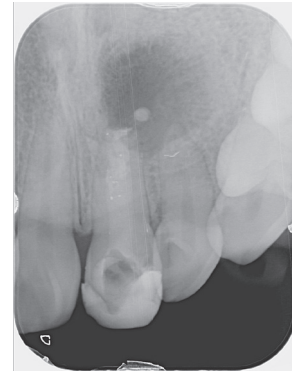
Post obturation periapical radiograph.
